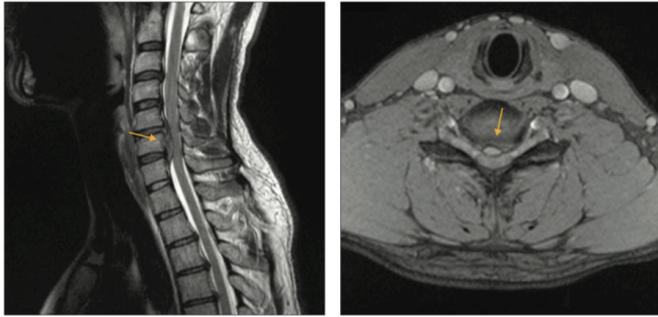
Sagittal T2-weighted magnetic resonance image demonstrating a large disc extrusion at C5-C6, which caused severe spinal canal stenosis and compression of the anterior cervical cord that extends to the C6-C7 level (arrow).
